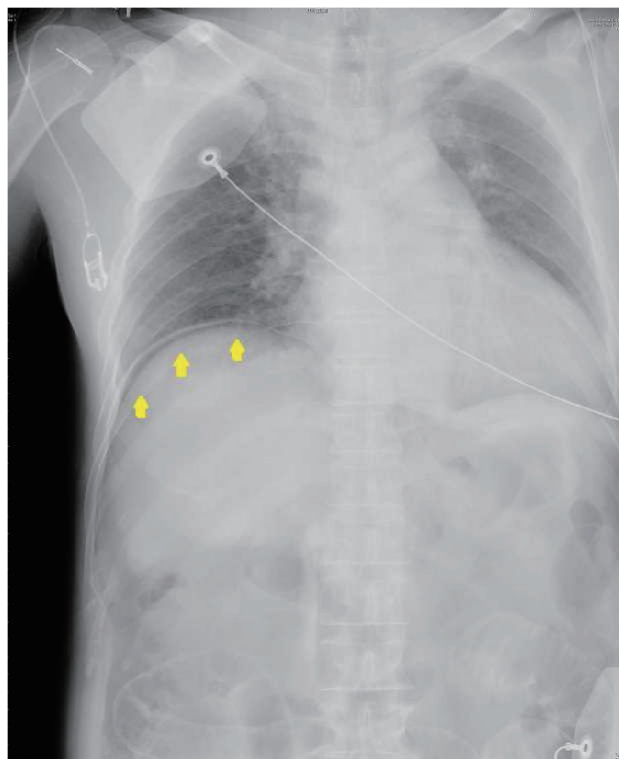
Chest radiograph showing large volumes of right subdiaphragmatic free air (arrows).
